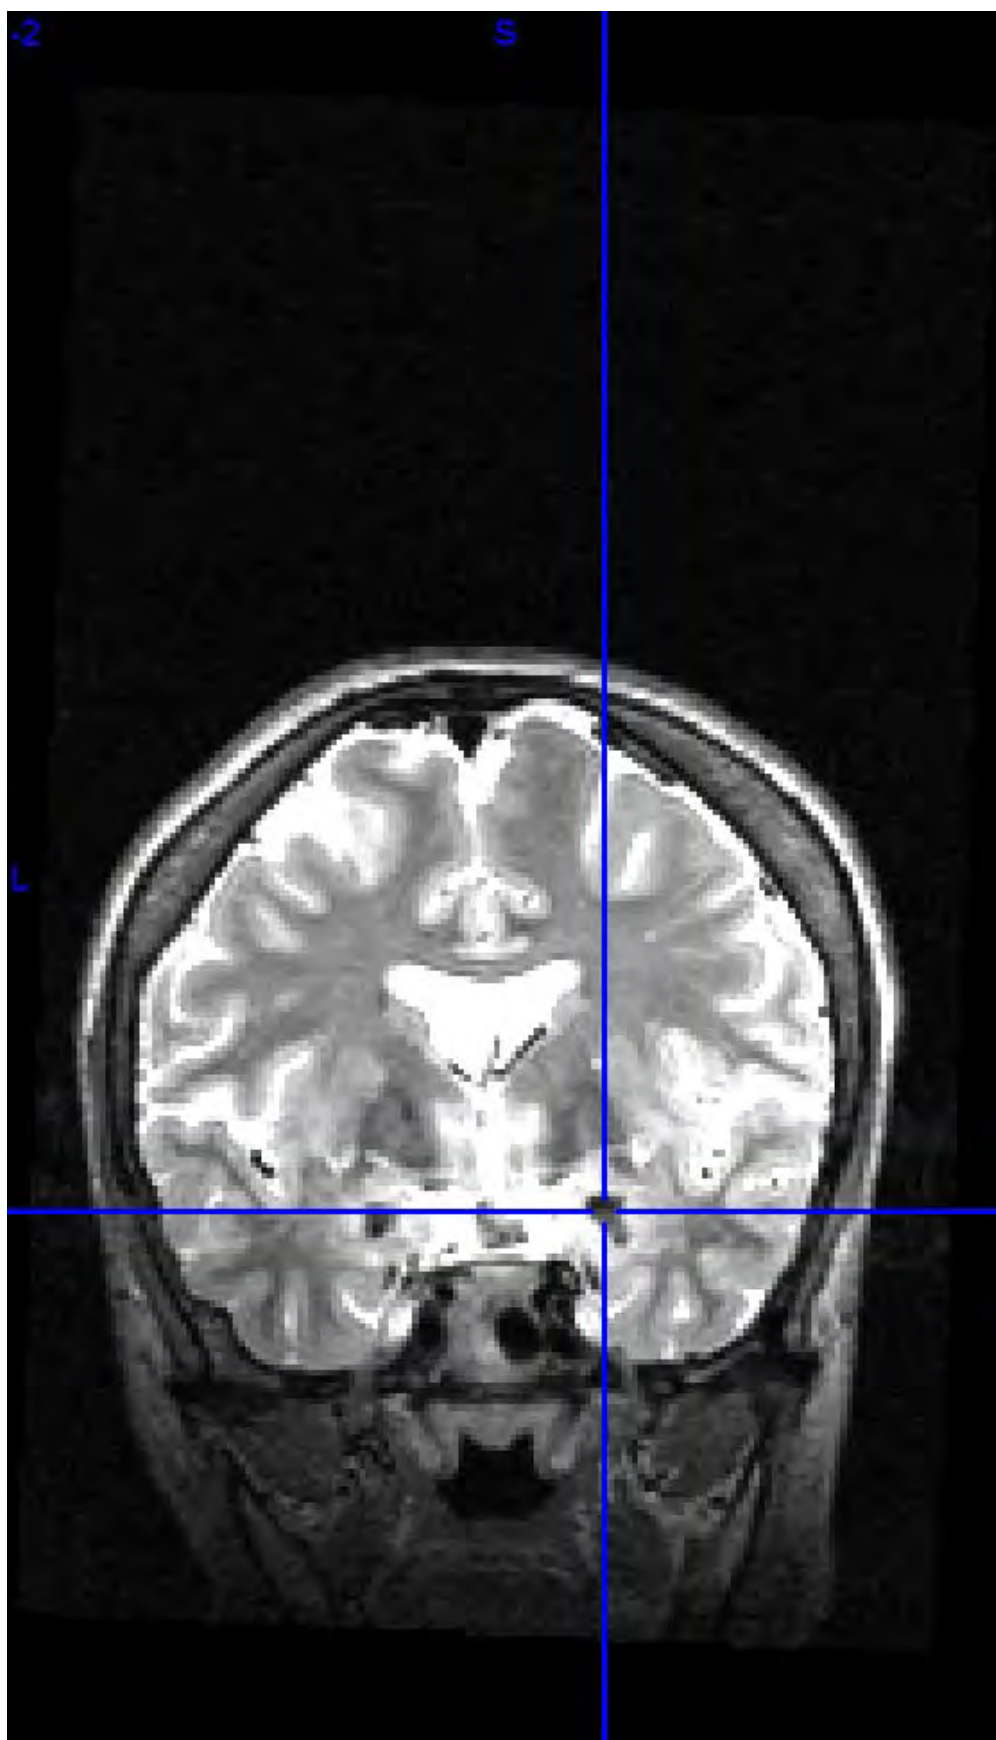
MRI scan for UWD patient no. 6.
